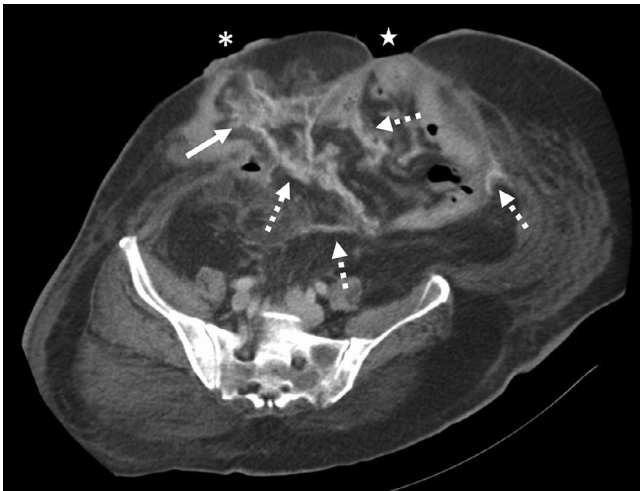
Early HMO. Transaxial CT scan taken less than 5 weeks from the initial CT scan demonstrates early ossification in the parastomal soft tissues at the site of surgical reduction (solid arrow). Interval development of multiple serpiginous densities extending toward the central abdomen along the mesenteric root (dashed arrows). The stoma site is only partially seen in this image (*). Midline incisional defect (star).
